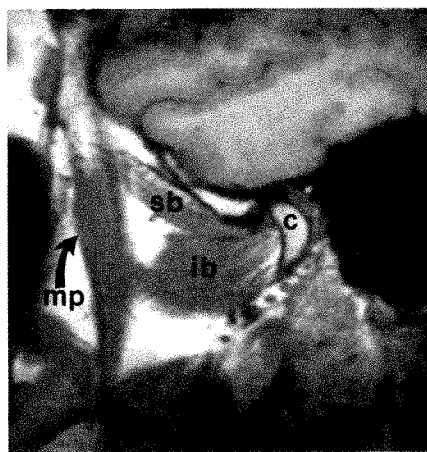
Normal pterygoid muscles and TMJ in 37-year-old male volunteer with average build. Sagittal, 3-mm-thick MR image, 500/20, with surface coil (with mouth closed in centric occlusion) reveals normal superior (sb) and inferior (ib) bellies of lateral pterygoids. mp = medial pterygoid, c = mandibular condyle.
